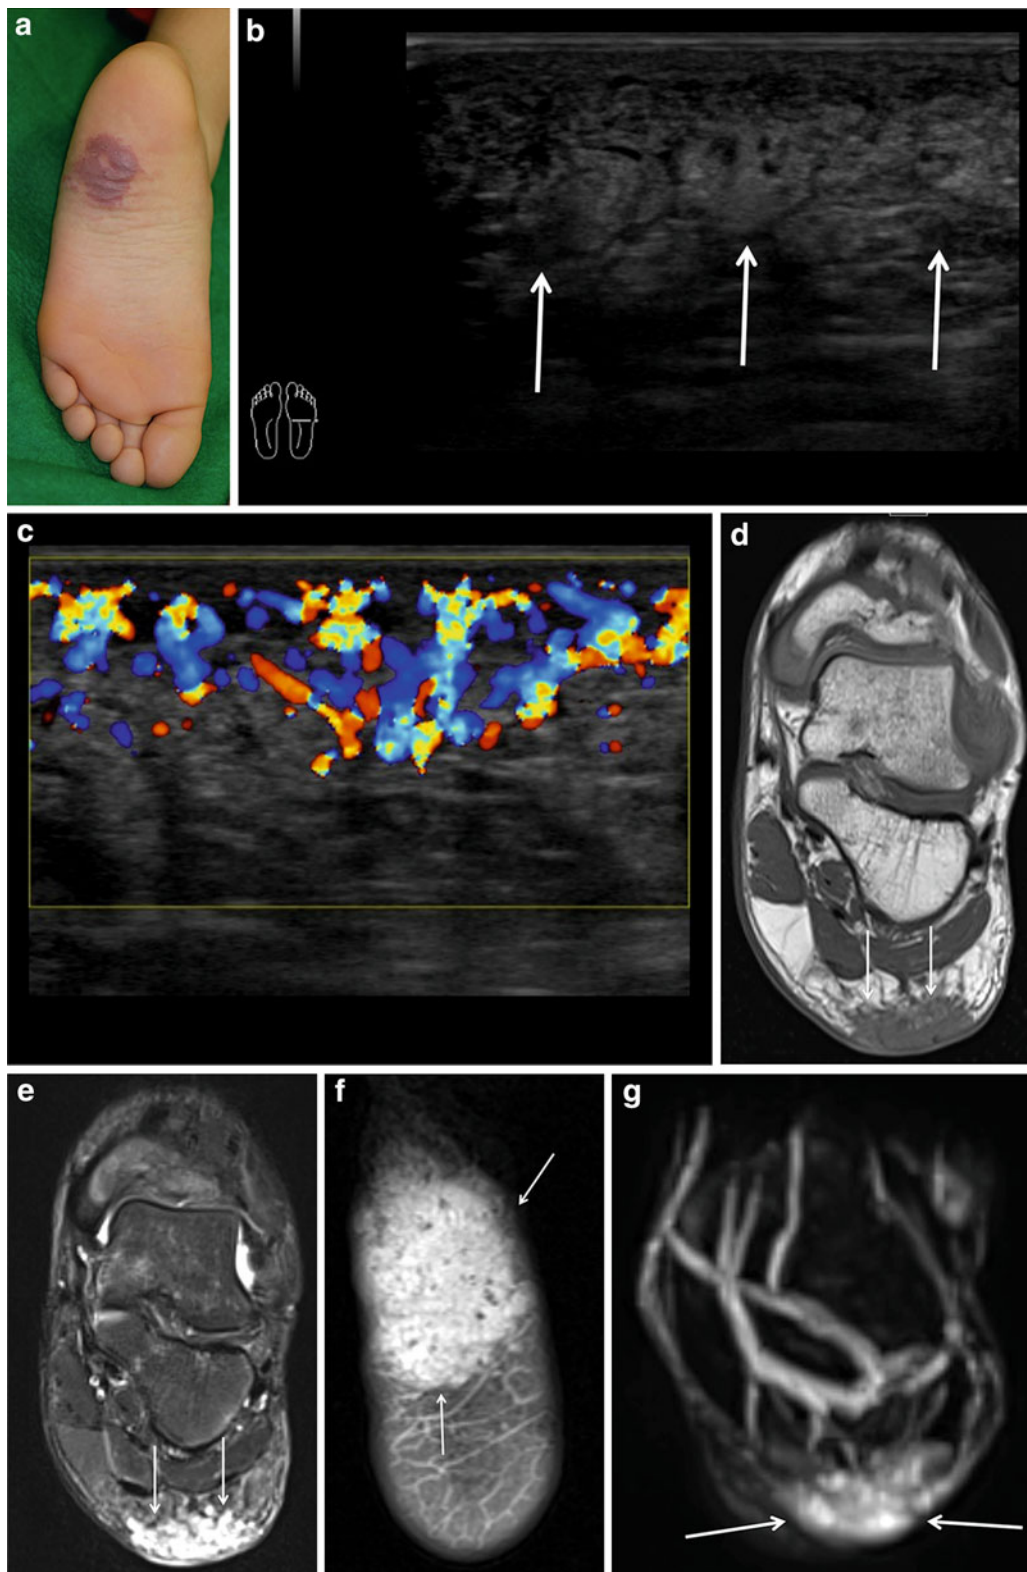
Non-involving congenital hemangioma (NICH) in the left sole. a A soft-tissue mass with reddish discoloration present since birth in a 12-year-old boy. b US shows ill-defined heterogeneous plantar solid mass (*arrows*). c Color Doppler US shows hypervascular mass with arterial flow. d Coronal T1-weighted MR image shows an ill-defined
